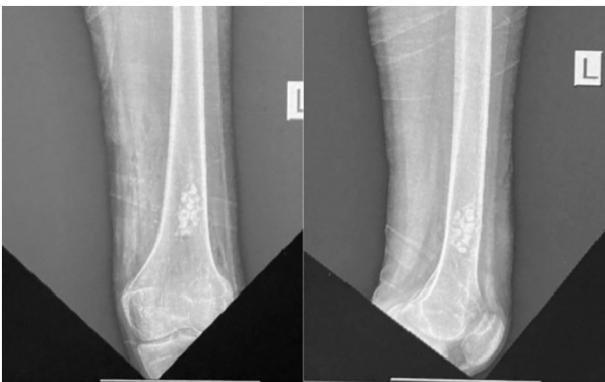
Follow up X-ray 3 months after the surgery showing no signs of post-operative complication.
